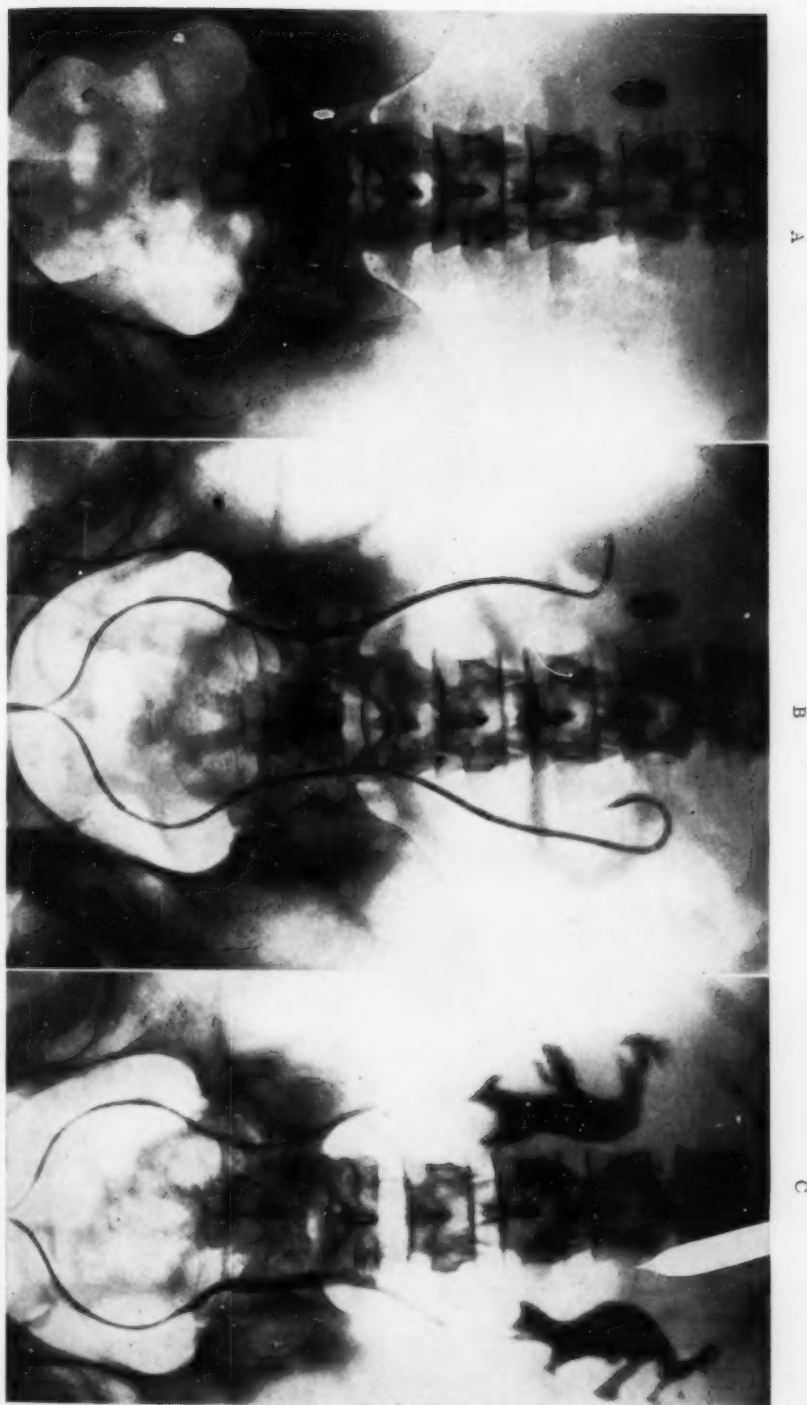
Radiographic and pyelographic findings in Case I. A print—Shadow of right renal calculus over outer end of right transverse process of second lumbar vertebra. B print—Note how right opaque catheter turns outward and left one inwards. C print—Note mesially directed calyces (see text) and unusual forms of both pyelograms; also close proximity of right one to spine.
